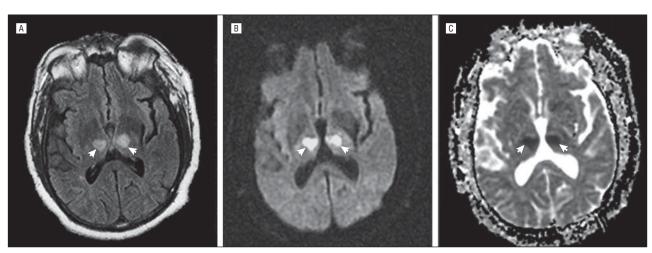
Magnetic resonance image of the brain indicating bilateral thalamic infarction. A, Fluid attenuated inversion recovery imaging showing high signal intensity in bilateral medial thalami (arrows). Axial diffusion-weighted image (B) and corresponding (C) apparent diffusion coefficient (ADC) map obtained 24 hours after symptom onset showing respective restricted diffusion and reduced ADC values (arrows), indicating acute bilateral paramedian thalamic infarction.
